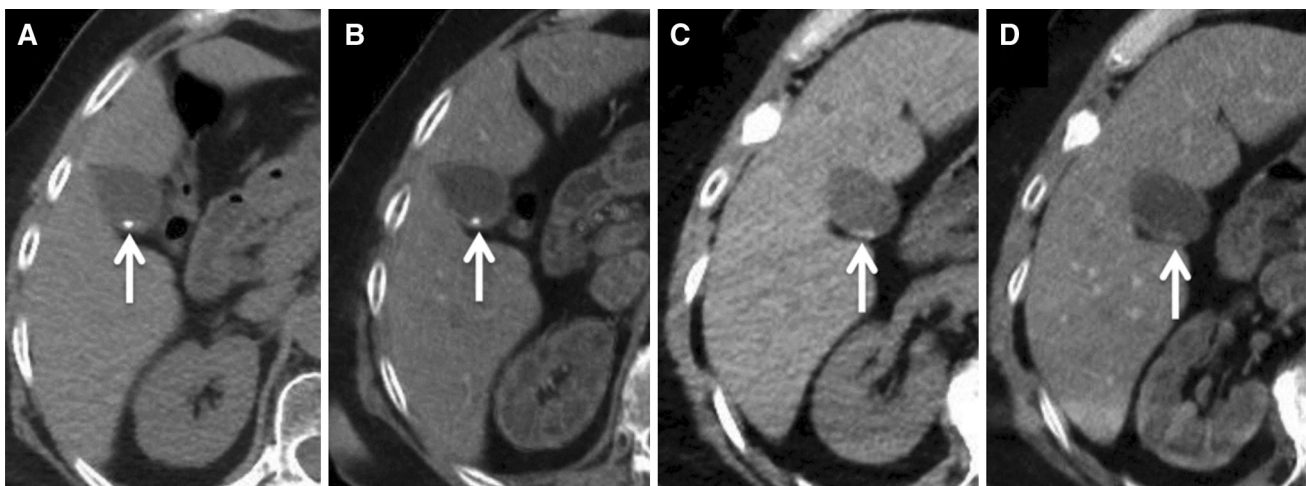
Evaluation of gallstones on conventional unenhanced CT and VUE images. A small calcified gallstone (*arrow*) is well depicted on both the conventional unenhanced CT (a) and the VUE image (b). However, a few tiny layering gallstones (*arrow*) are poorly seen on
